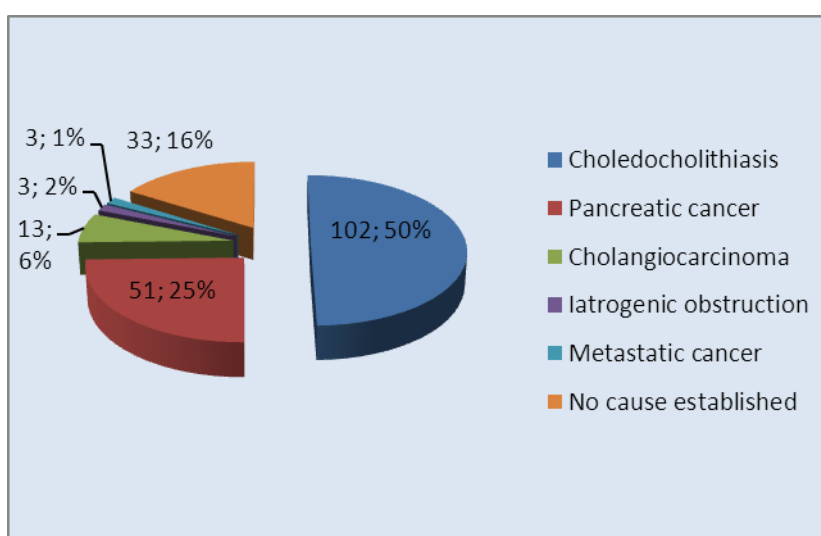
№ 7 Ultrasound findings at the level of the common bile duct (n=205)
